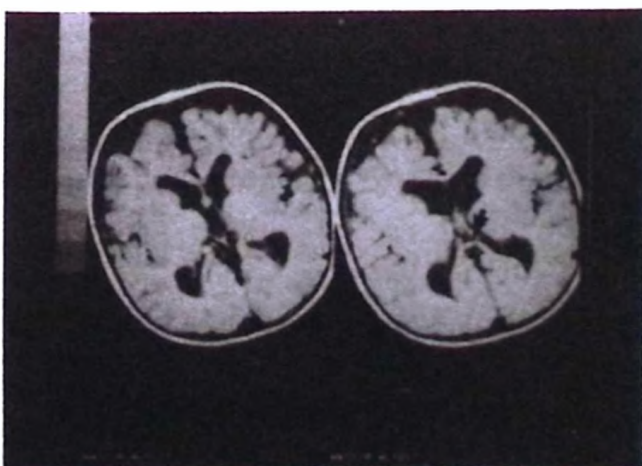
Brain magnetic resonance imaging (MRI) of Case 2 demonstrates cortical atrophy, and hypoplasia of corpus callosum (arrow).
